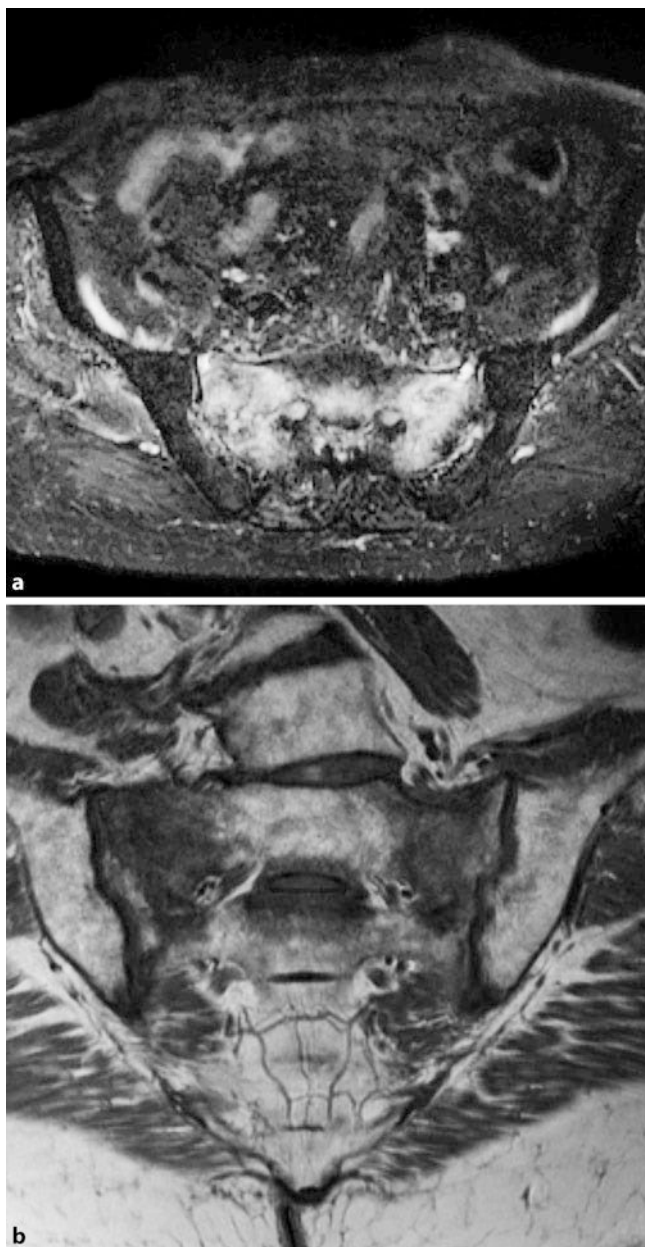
MRI of the sacrum in a postmenopausal patient after cortisone therapy. a On the STIR sequence, evidence of a regional oedema with bilateral fatigue fracture of the sacrum. b On the coronal T1-weighted image the fracture lines are shown as hypointensity
